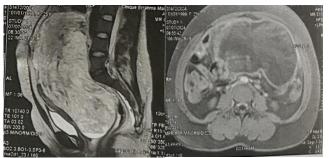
Abdominal and pelvic MRI showing a large 19\*12\*25 cm abdominopelvic mass of left ovarian solid cystic origin, predominantly tissue.
